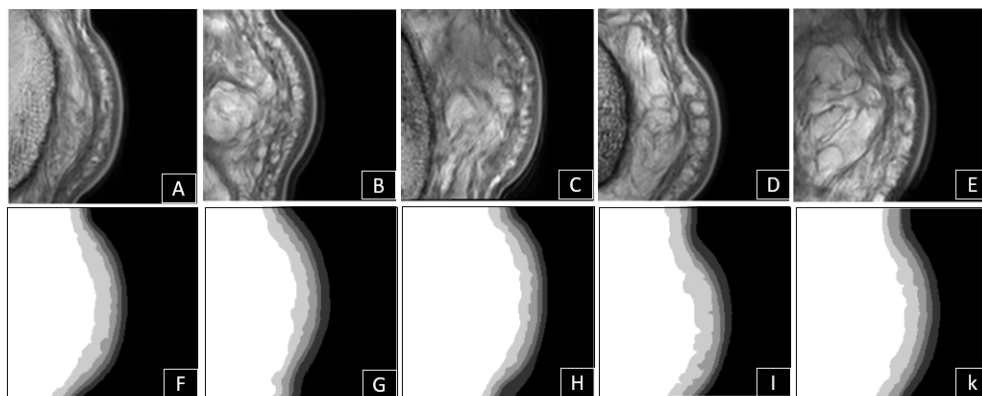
Augmented MRI images:A, B, C, D, and E augmented images. F,G, H, I and K resp augmented masks.
